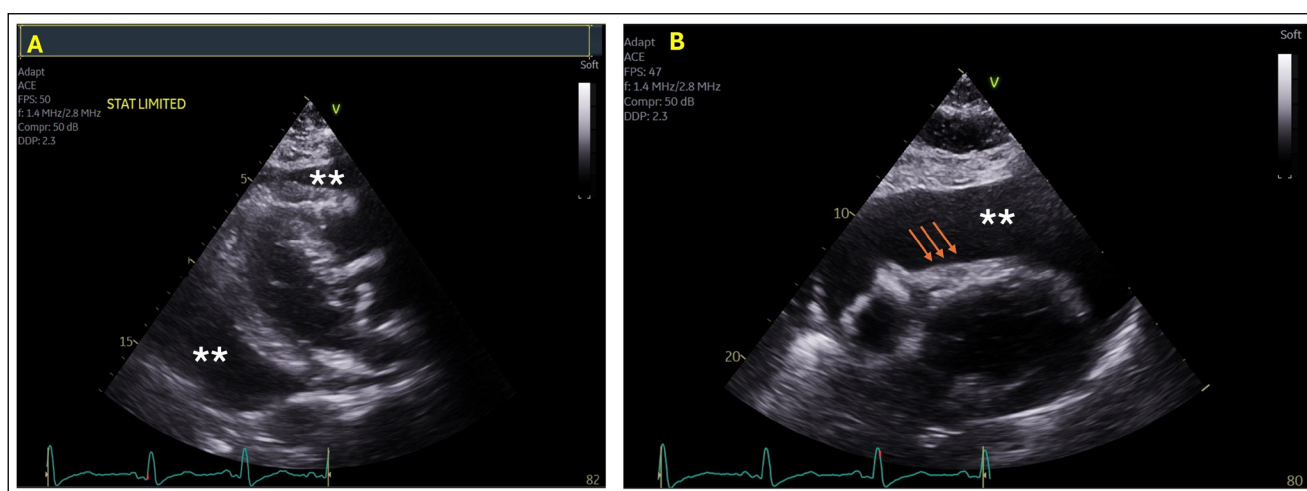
Transthoracic echocardiogram, parasternal long-axis view (Panel A), and subcostal view (Panel B) showing large circumferential pericardial effusion (asterisks) with right ventricular diastolic collapse (arrows).
